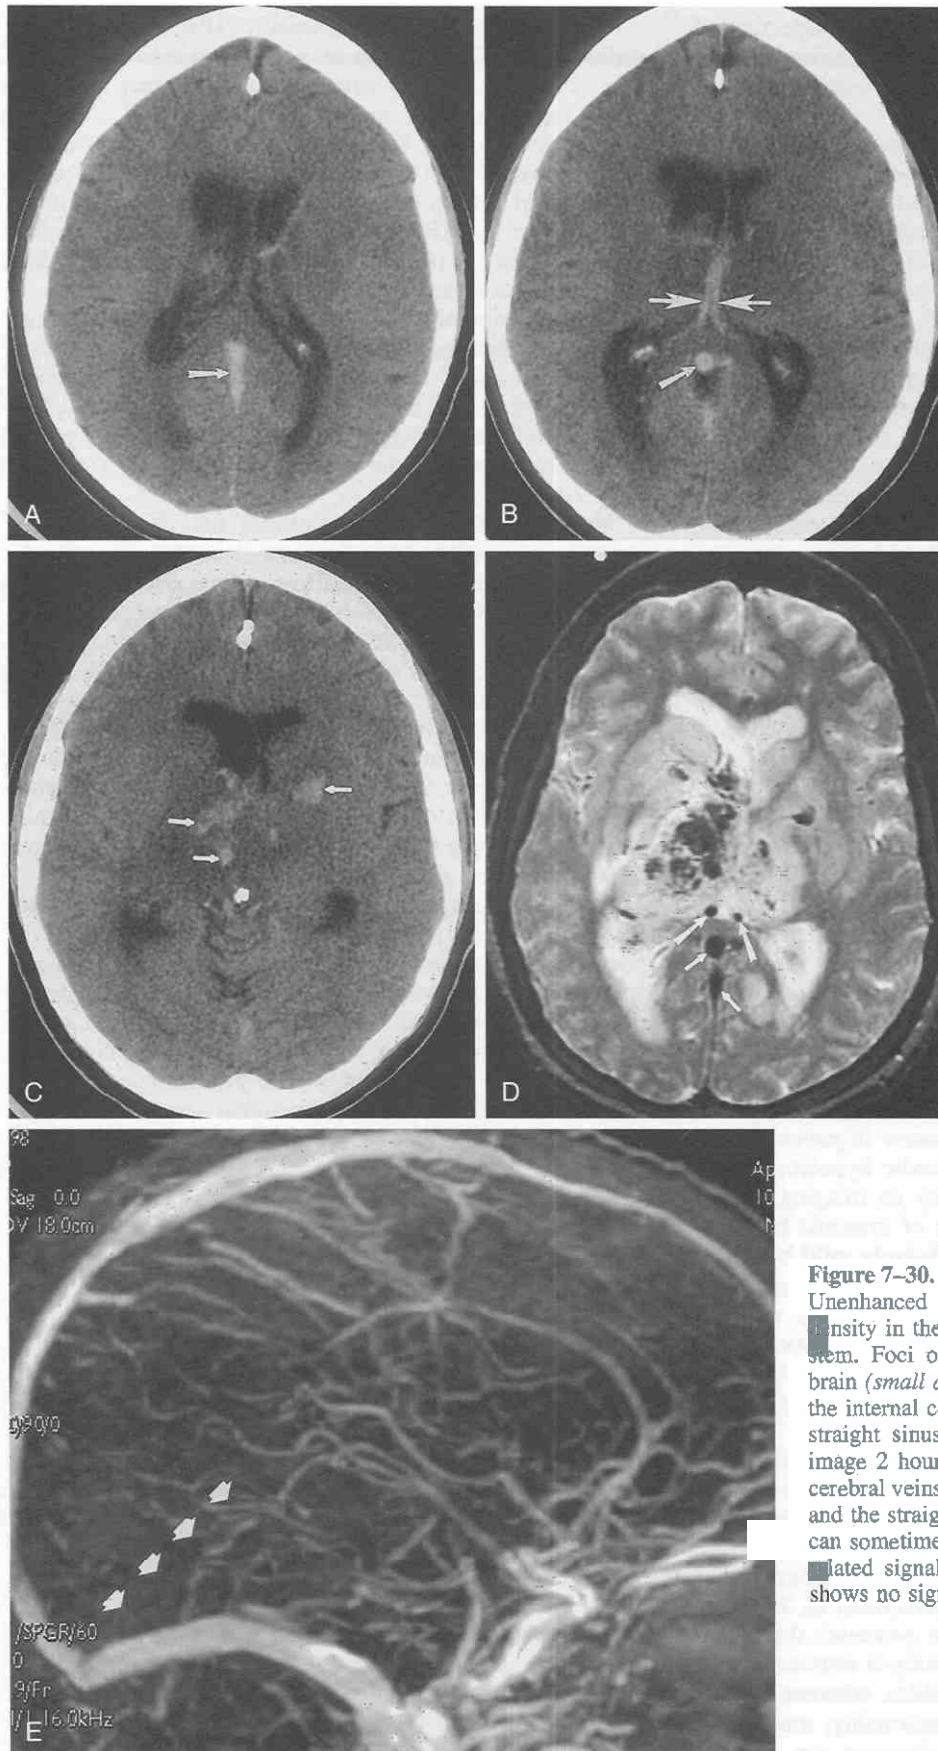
Deep cerebral venous thrombosis. A–C, Unenhanced axial CT images show extensive low density in the basal ganglia, thalami, and upper brain stem. Foci of hemorrhage are also seen within the brain (*small arrows*). Increased density is seen within the internal cerebral veins, the vein of Galen, and the straight sinus (*larger arrows*). D, T2-weighted MR image 2 hours later shows low signal in the internal cerebral veins (*larger arrows*) and in the vein of Galen and the straight sinus (*small arrows*). Acute thrombus can sometimes appear as low signal, mimicking flow-related signal void. E, Time-of-flight MR venogram shows no signal in the straight sinus (*small arrows*).
